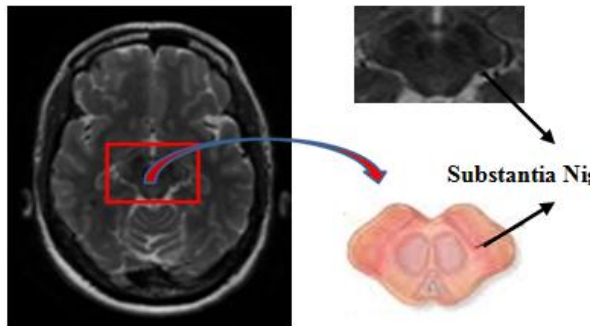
MRI image before and after ROI.
